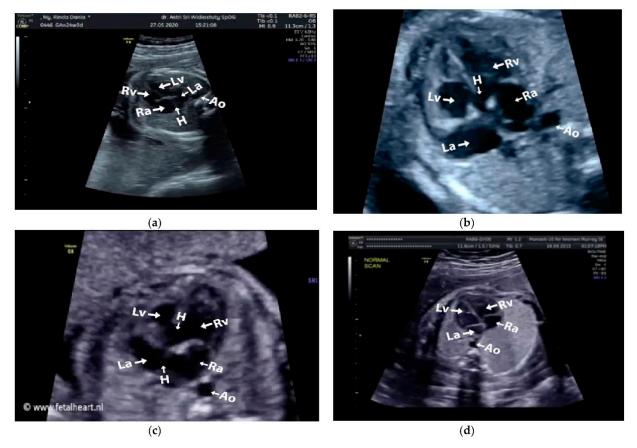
A 2 – D ultrasonography of the fetal heart in 4 chamber view for congenital heart defects detection at 18weeks of gestation: (a) ASD, (b) VSD, (c) AVSD, and (d) Normal Left ventricle (LV), left atrium (LA), right ventricle (RV), right atrium (RA), aorta descendens (AO), hole (H) (Nurmaini et al., 2021)
